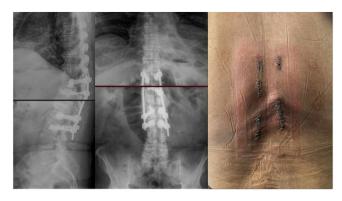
Postoperative lateral (left image)/AP (centre image) X-rays and percutaneous wounds (right image).
